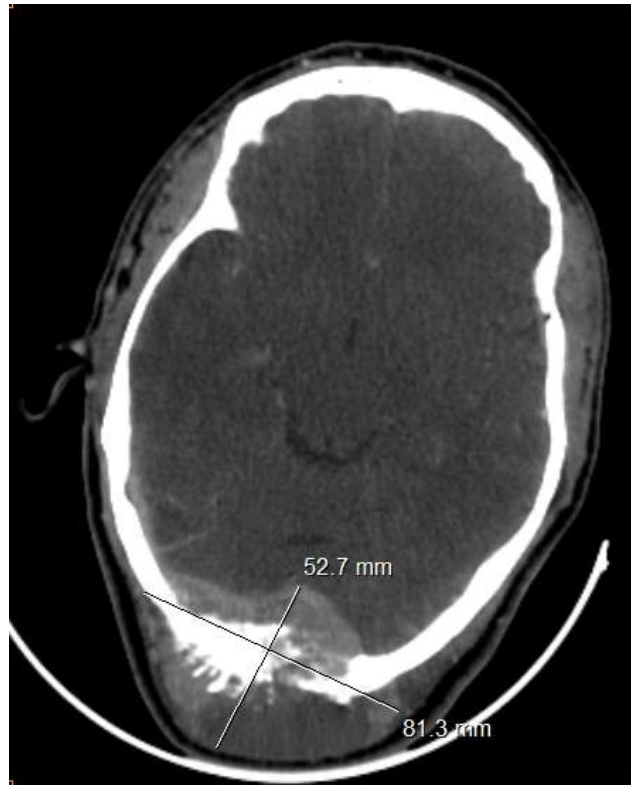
Cerebral injected CT scan of our case, showing the osteolytic tumour of the occipital bone with intracranial and soft tissue invasion.
